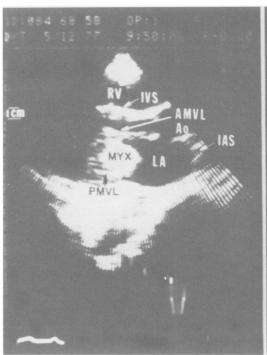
Two-dimensional sagittal echocardiogram showing mobile tumor prolapsing into left ventricle during diastole (left) and returning to left atrium during systole (right). RV = right ventricle; IVS = interventricular septum; AMVL = anterior mitral valve leaflet; Ao = aorta; IAS = atrial septum; MYX = myxoma; PMVL = posterior mitral valve leaflet (Reprinted with permission from Lappe DL, Bulkley BH, Weiss JL. Two-dimensional echocardiographic diagnosis of left atrial myxoma. Chest 1978; 74:55.
